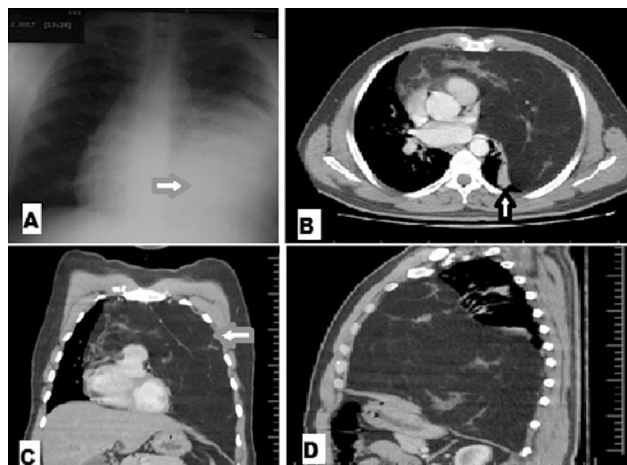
A: chest xray PA view shows opaque left mid and lower zone (arrow), B-D: Contrast enhanced CT scan in various planes shows a heterogenous fat attenuated lesion in anterior mediastinum (Gray arrow) extending into hemithoraces with atelectasis (black arrow) of left lower lobe and lingular segment.
